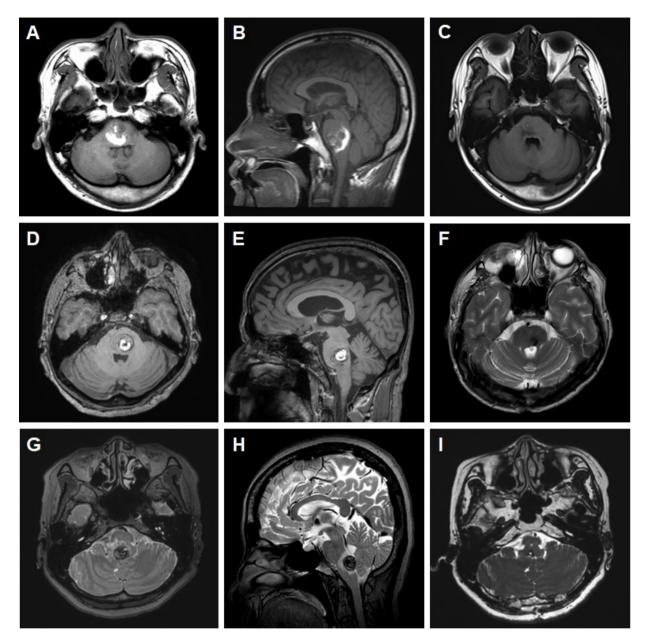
Preoperative and postoperative images of the cavernous malformation (CM) resected via the telovelar approach. (A, B) Axial and sagittal T1 images of preoperative magnetic resonance imaging reveal that the CM is located in the pons with recurrent bleeding; hemorrhage is near the fourth ventricle, which makes the telovelar approach suitable. (C) Postoperatively, CM is completely removed without any surgical complication. (D, E) The CM is in the lower pons, close to the floor of the fourth ventricle. (F) The lesion is resected via the telovelar approach. (G, H) Axial and sagittal T2 images show that the CM is located mainly in the medulla, and is protruded to the fourth ventricle. (I) The lesion is completely removed using the telovelar route.
